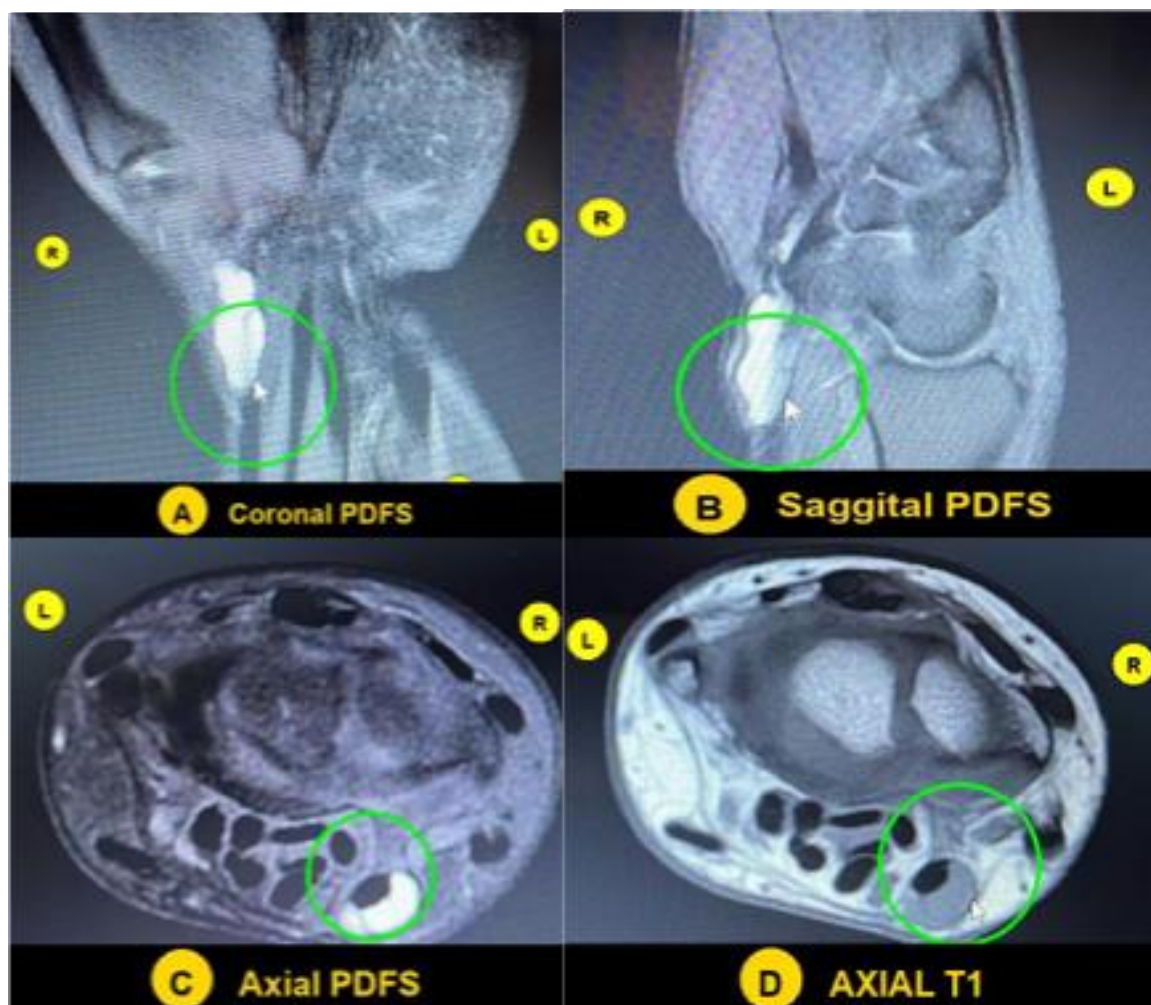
Patient came with complaints of palpable swelling at the palmar aspect with mild pain and discomfort. Case shows MRI of the left wrist joint. The Axial T1 (A), Coronal PDFS (B), Sagittal PDFS (C), and Axial PDFS (D) sequences demonstrate a well-defined, lobulated, septated cystic lesion at the palmar aspect of the wrist along the FCR (Flexor Carpi Radialis) tendon. The lesion appears hyperintense on T2 and PDFS sequences (B, C, D) and hypointense on the T1 sequence (A), representing a Ganglion Cyst (GC).
